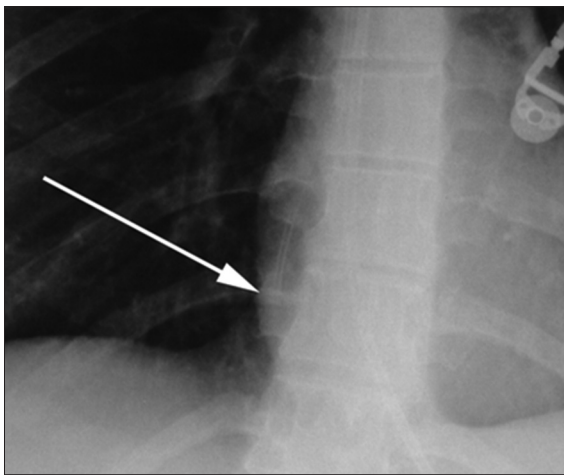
Catheter misplacement to the pericardium.^[6] Chest radiograph reveals that the tip of the catheter is seen to lie within the right atrium (arrow).
